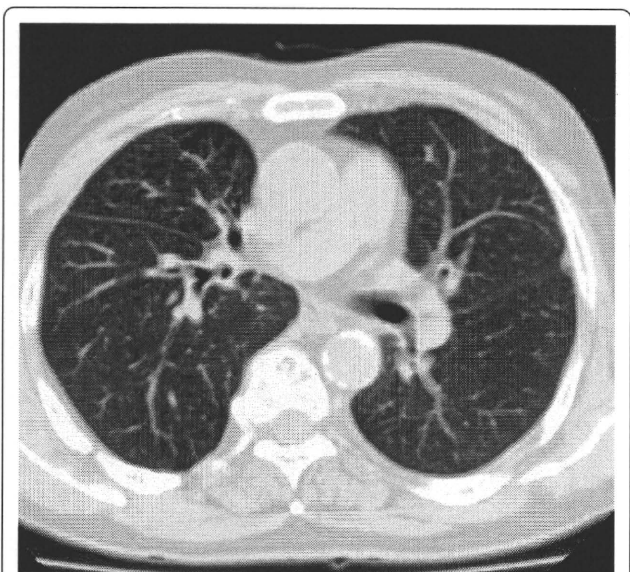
CT images before SBRT (Pt. No. 7).
